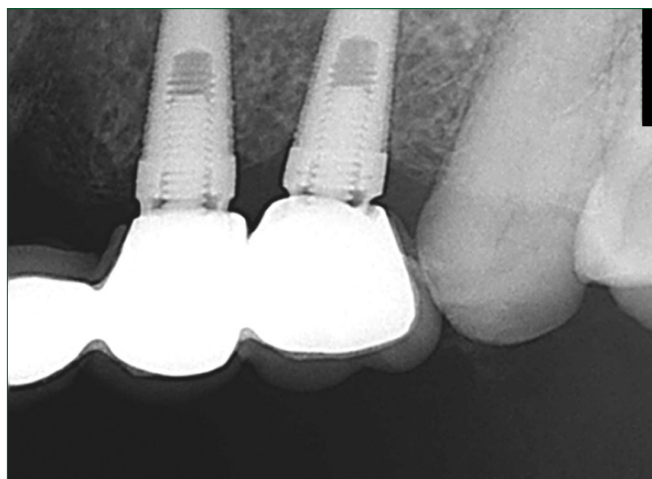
Intraoral radiograph immediately after cementation showing the splinted implants in the prosthesis
